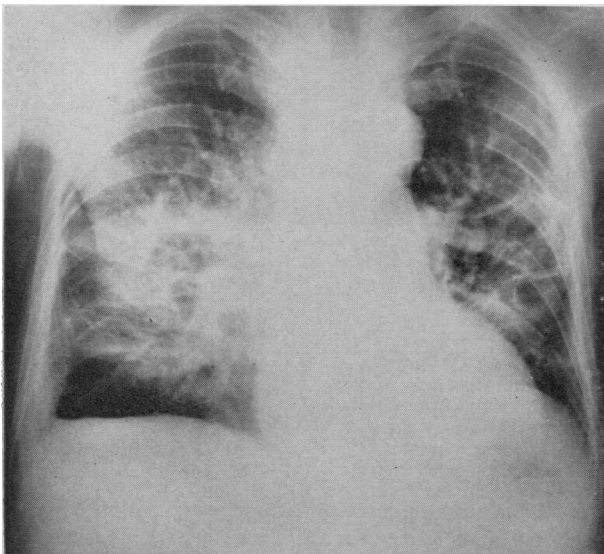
Chest radiograph showing well-marked fibrosis.
